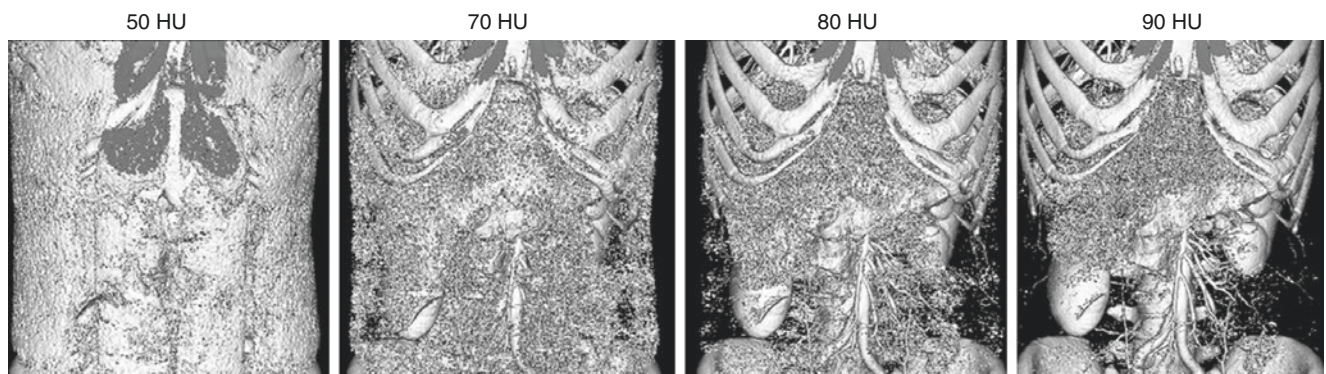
Image segmentation of hepatic anatomy using CT number thresholding technique. After applying the minimum CT attenuation of 50 HU, 70 HU, 80 HU and 90 HU to the volume data, hepatic anatomy cannot be clearly visualised in the segmented data due to its attenuation
